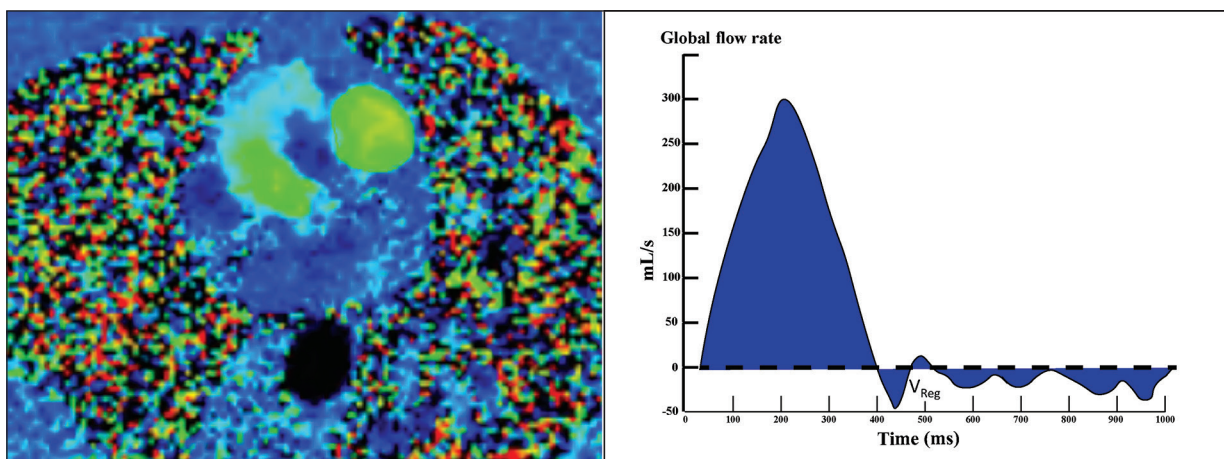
Phase-contrast CMR of a 49-year-old patient with systemic sclerosis representing the pulmonary artery (A) and specific characteristics regarding forward and backward flow characteristics (B). *Abbreviations:* CMR, cardiac magnetic resonance imaging.
